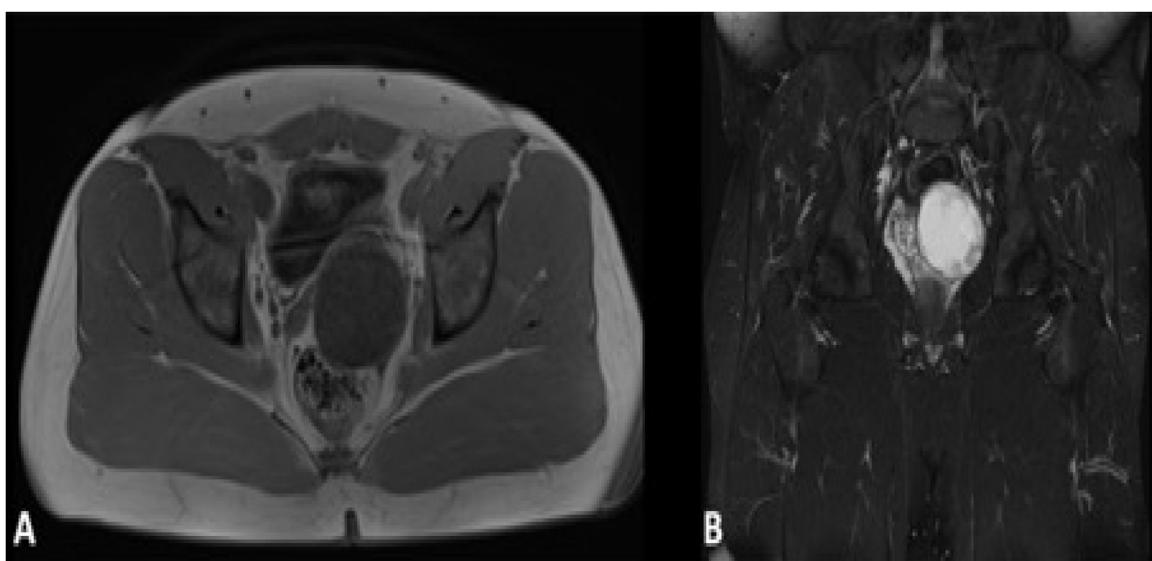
Initial MRI of the pelvis. A: Axial T1, B: Coronal T2. T1 hypo intense and T2 bright/hyperintense well-defined mass arising from the left anterior rectal wall with luminal narrowing. The mass has peripheral areas of hypointense signals highlighting a more fibrous nature. There is a marked displacement of the bowel loops with a moderate amount of compression on the posterior bladder wall. No local infiltration is evident.
